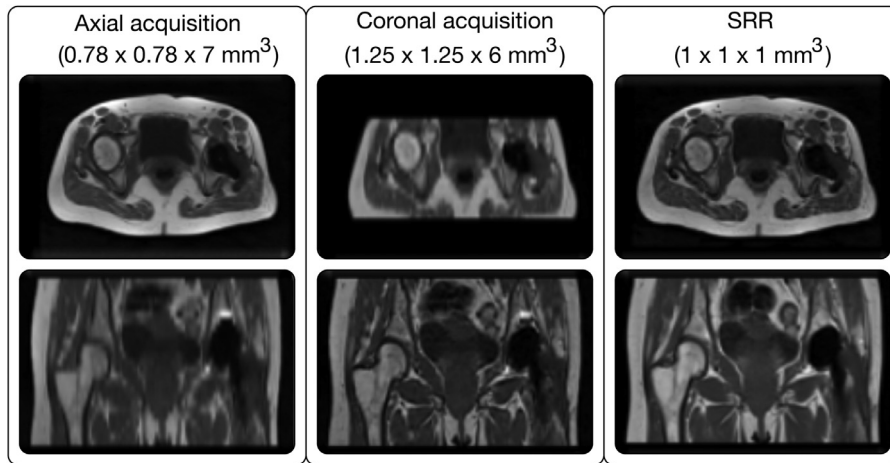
Example of the available input axial and coronal MRI acquisitions and the respective super-resolution reconstructed (SRR) MRI, showing how low-resolution information is combined to maintain high resolution in both the imaging planes.
